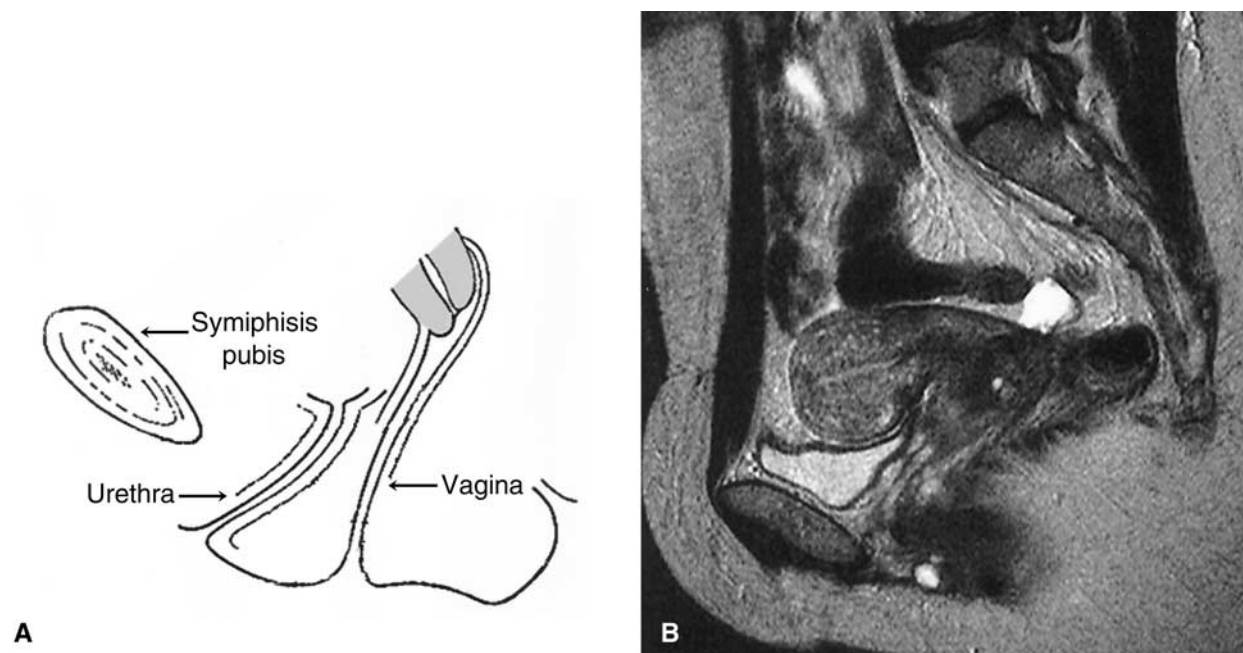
Scheme (A) and corresponding sagittal turbo spin-echo T2-weighted image (B) show the inclination of the female neovagina.
